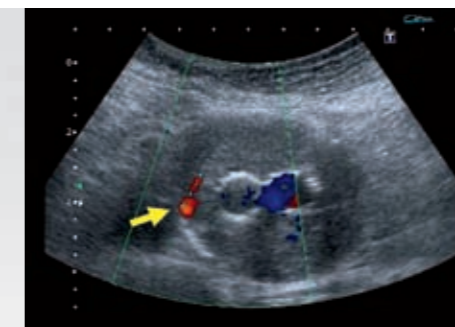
Color Doppler US: color flow signal within the aneurysmal sac, on the right side.
